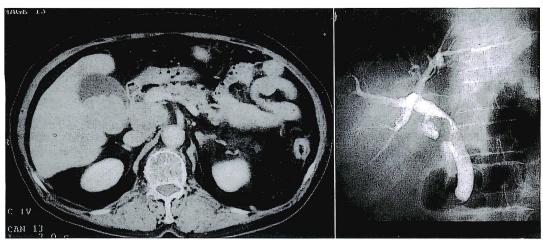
Abdominal CT demonstrating a large, hyperdensity mass occupying the neck and body of the gallbladder (left) and ERC showing a filling defect in the middle portion of the common bile duct and occlusion of the cystic duct (right).
